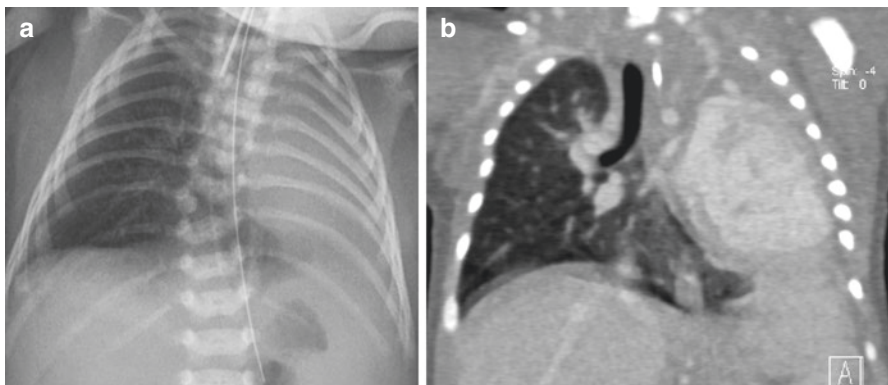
Newborn with congenital unilateral lung agenesis on the left side. X-ray with complete shifting of the mediastinum to the right side (a). Corresponding CT scan with complete absence of the left lung (b)
